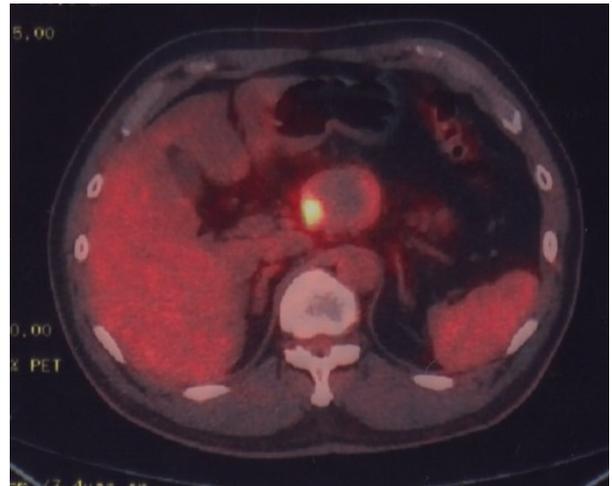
Positron emission tomography images using F-18 fluorodeoxyglucose: The intracystic projection was positively visualized (SUVmax: 5.8).
